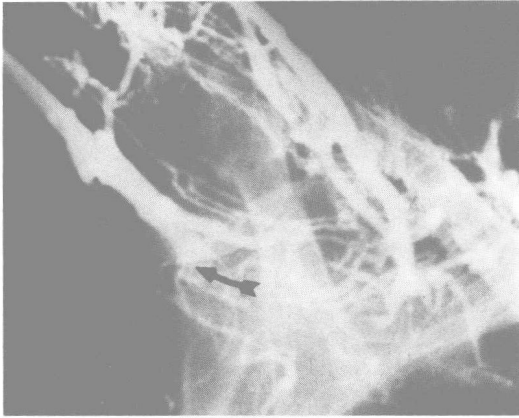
Arrow indicates site of primary thrombosis of the axillary vein (Paget-von Schrötter syndrome). (Steinberg, I.: *Amer. J. Roentgen.*, 98:388, 1966)
